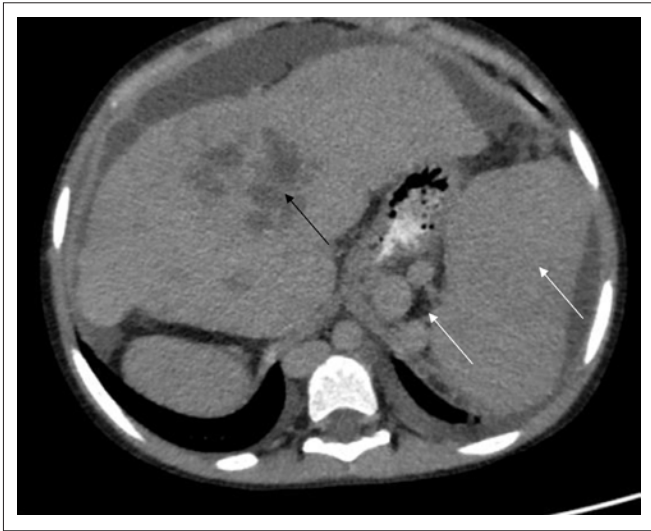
CT Abdomen indicating polysplenia (white arrows) and a midline liver with an abscess (black arrow).
